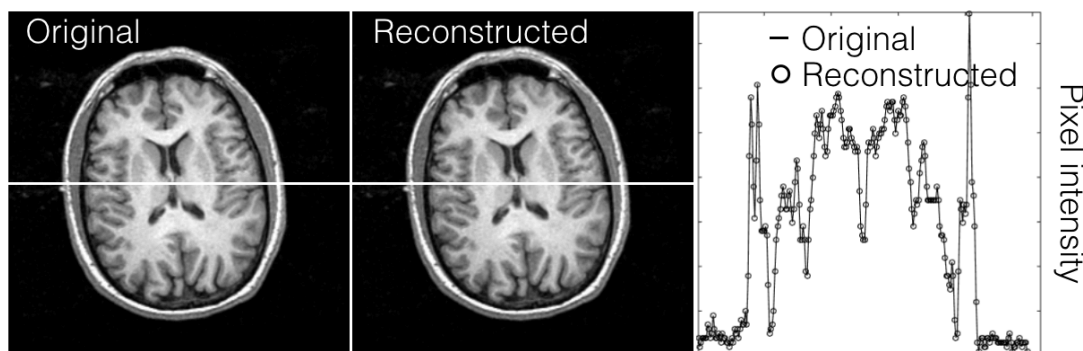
(Left) Brain MR image compared to the reconstructed image (middle) with only a subset of the wavelet sub-bands. On the right, a 2D plot compares the the middle row intensity profiles of an axial plane between the images.
